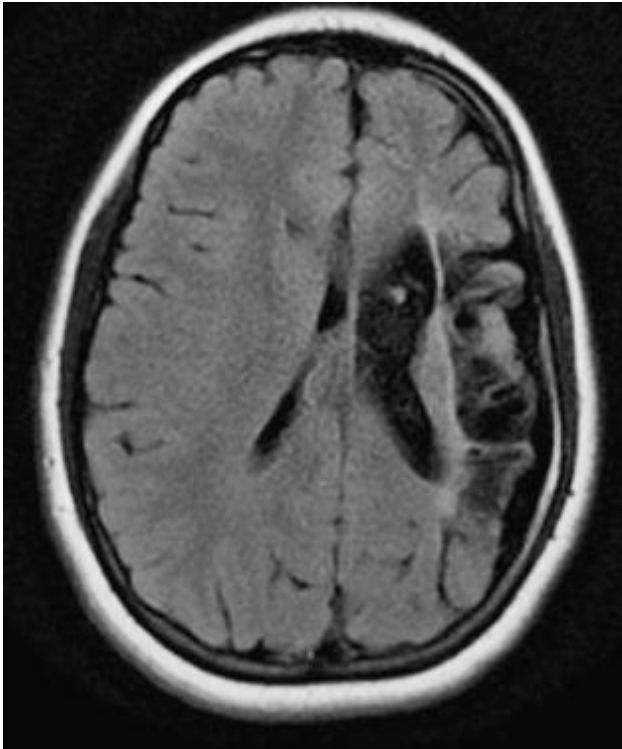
MRI brain revealed hemiatrophy of left cerebral hemisphere.
